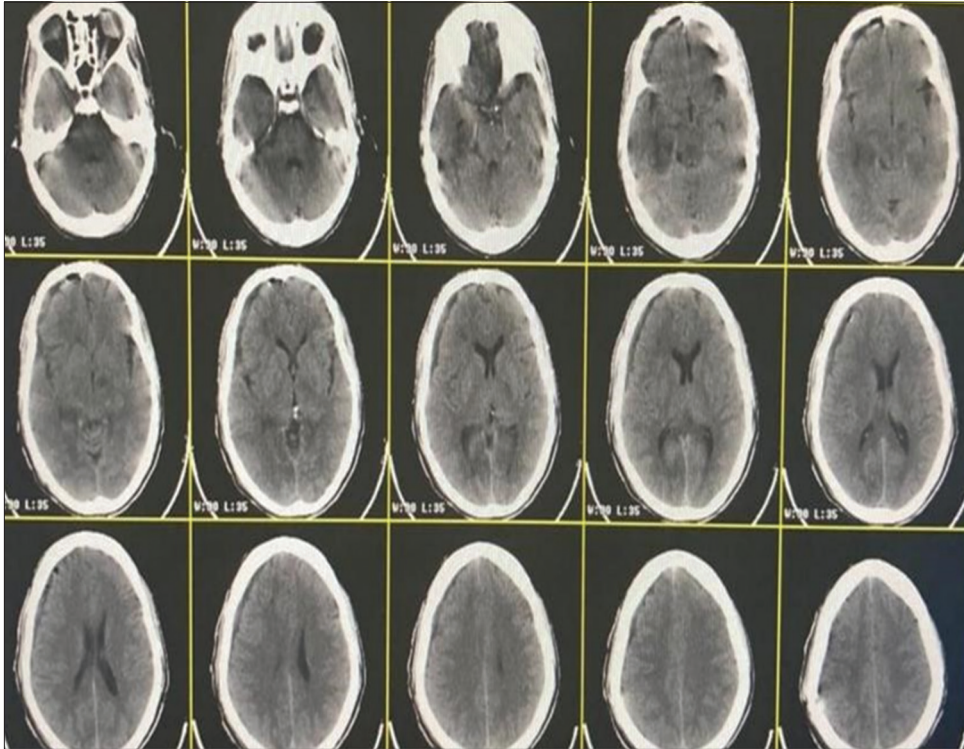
Repeat non-contrast computed tomography on POD 2 showing good evacuation of hematoma and resolution of mass effect hyperdensity along right convexity
